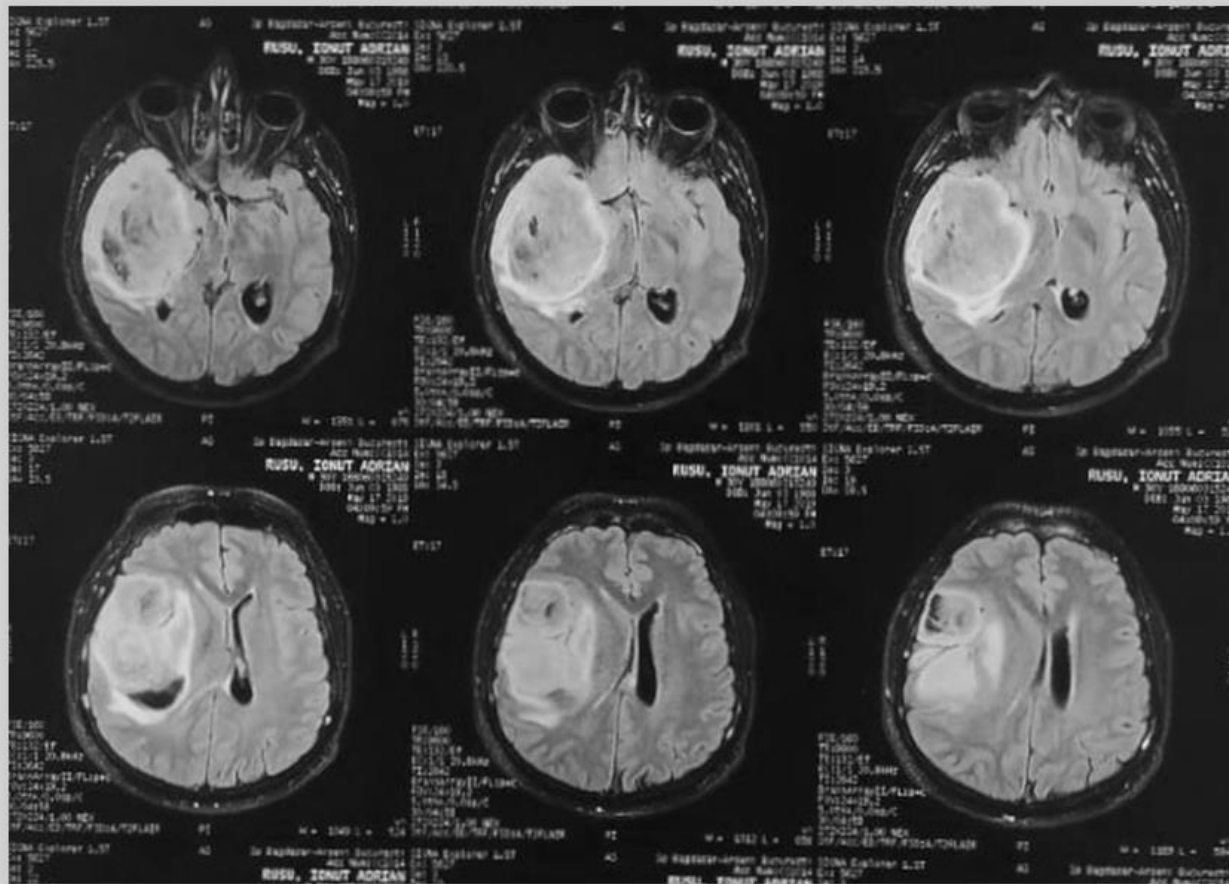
Gadolinium enhanced MRI scan, axial section, showing a right fronto-temporal tumour, measuring 9.5 cm in diameter, compressing the adjacent structures with inhomogenous enhancement.
